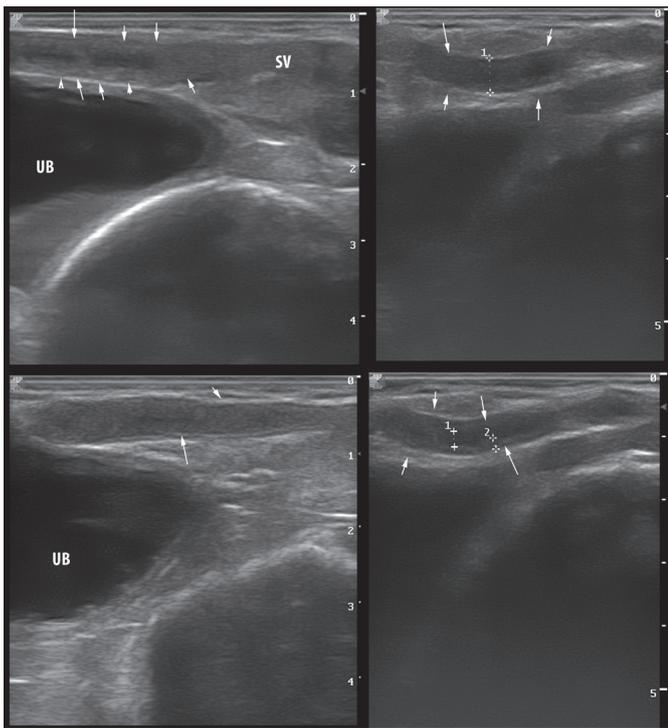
Transrectal ultrasonography of the normal ampulla of the vas deferens. Note the tick muscular wall and the presence of a clear lumen
